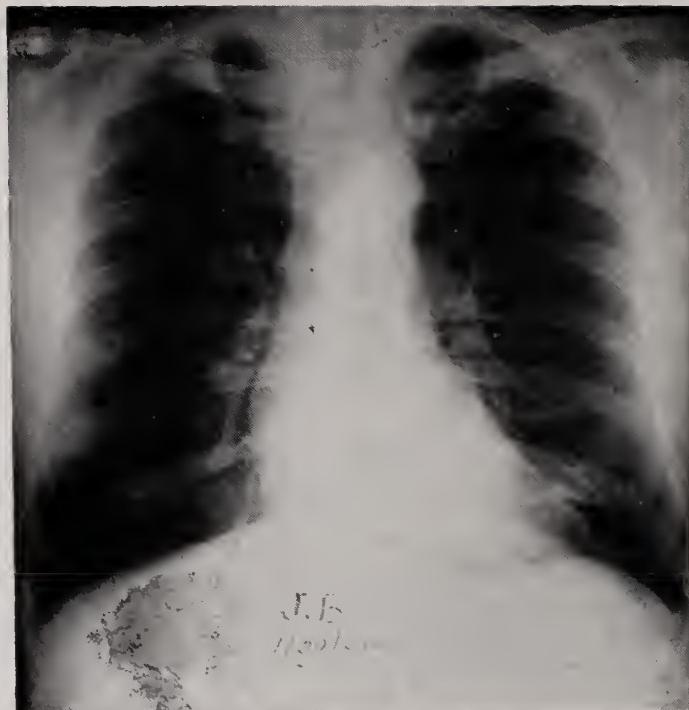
Roentgenograms of the chest (PA) on January 30, 1956 showing no abnormality.
